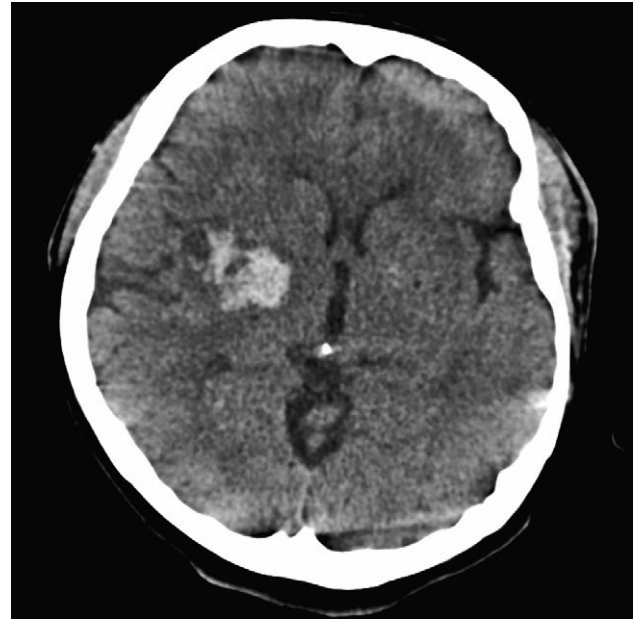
CT scan of the brain showing an intracerebral haemorrhage in the right hemisphere.
